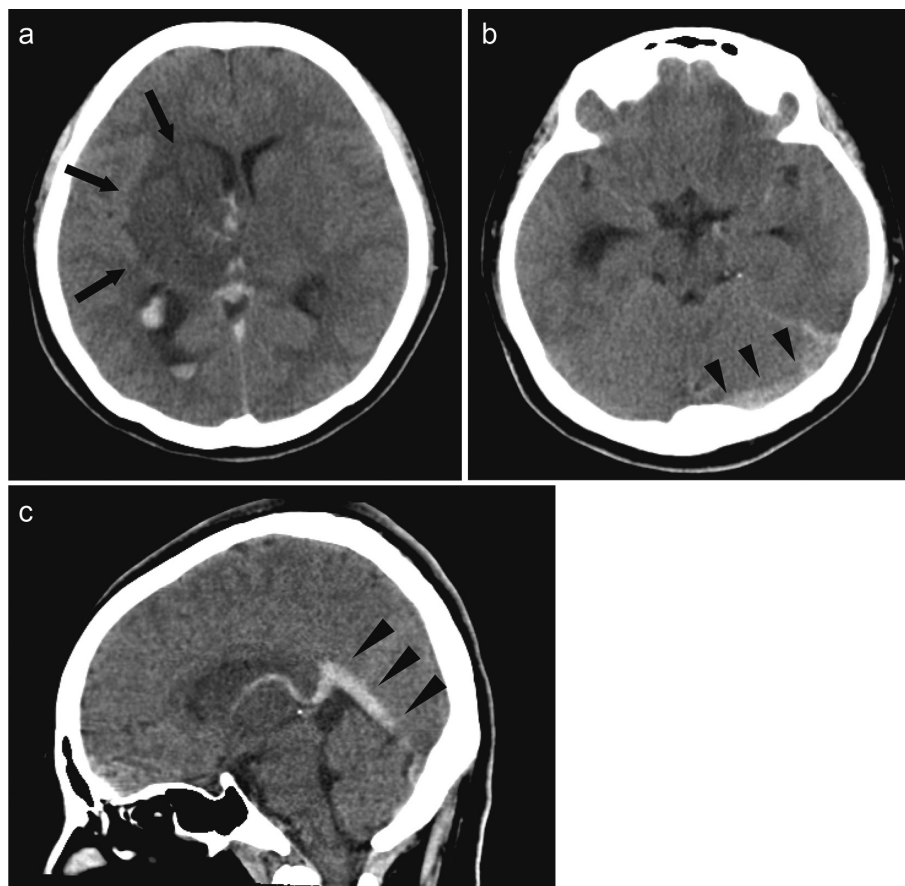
Computed tomography scan of the head at admission.
